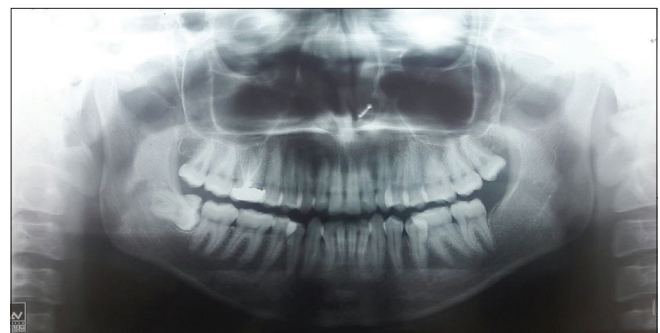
Pre-treatment orthopantomograph.
